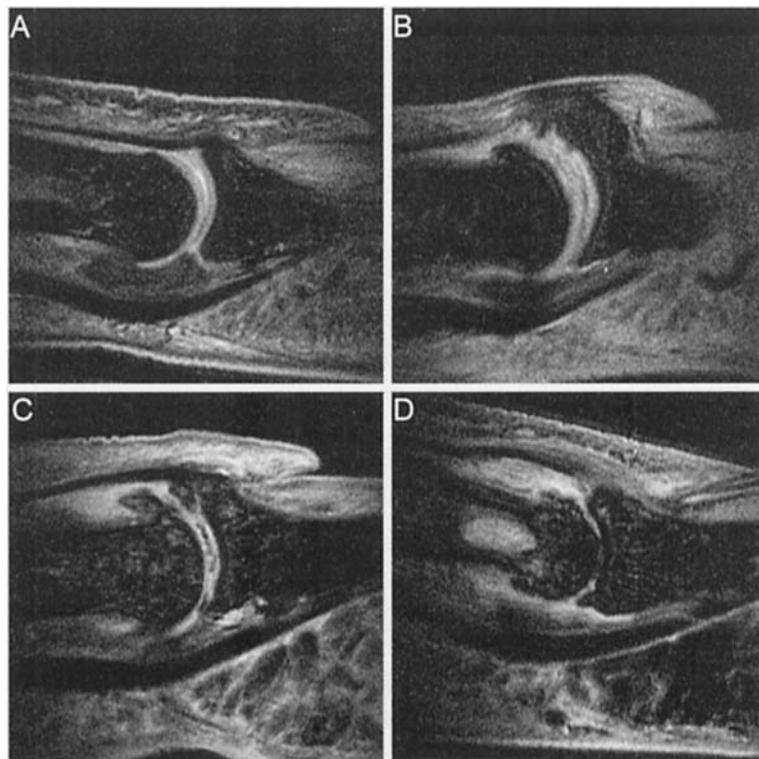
Coronal views of spin echo, fat suppressed MR images of the DIP joint (TR 1500, TE 30 ms with chemical shift selection).
